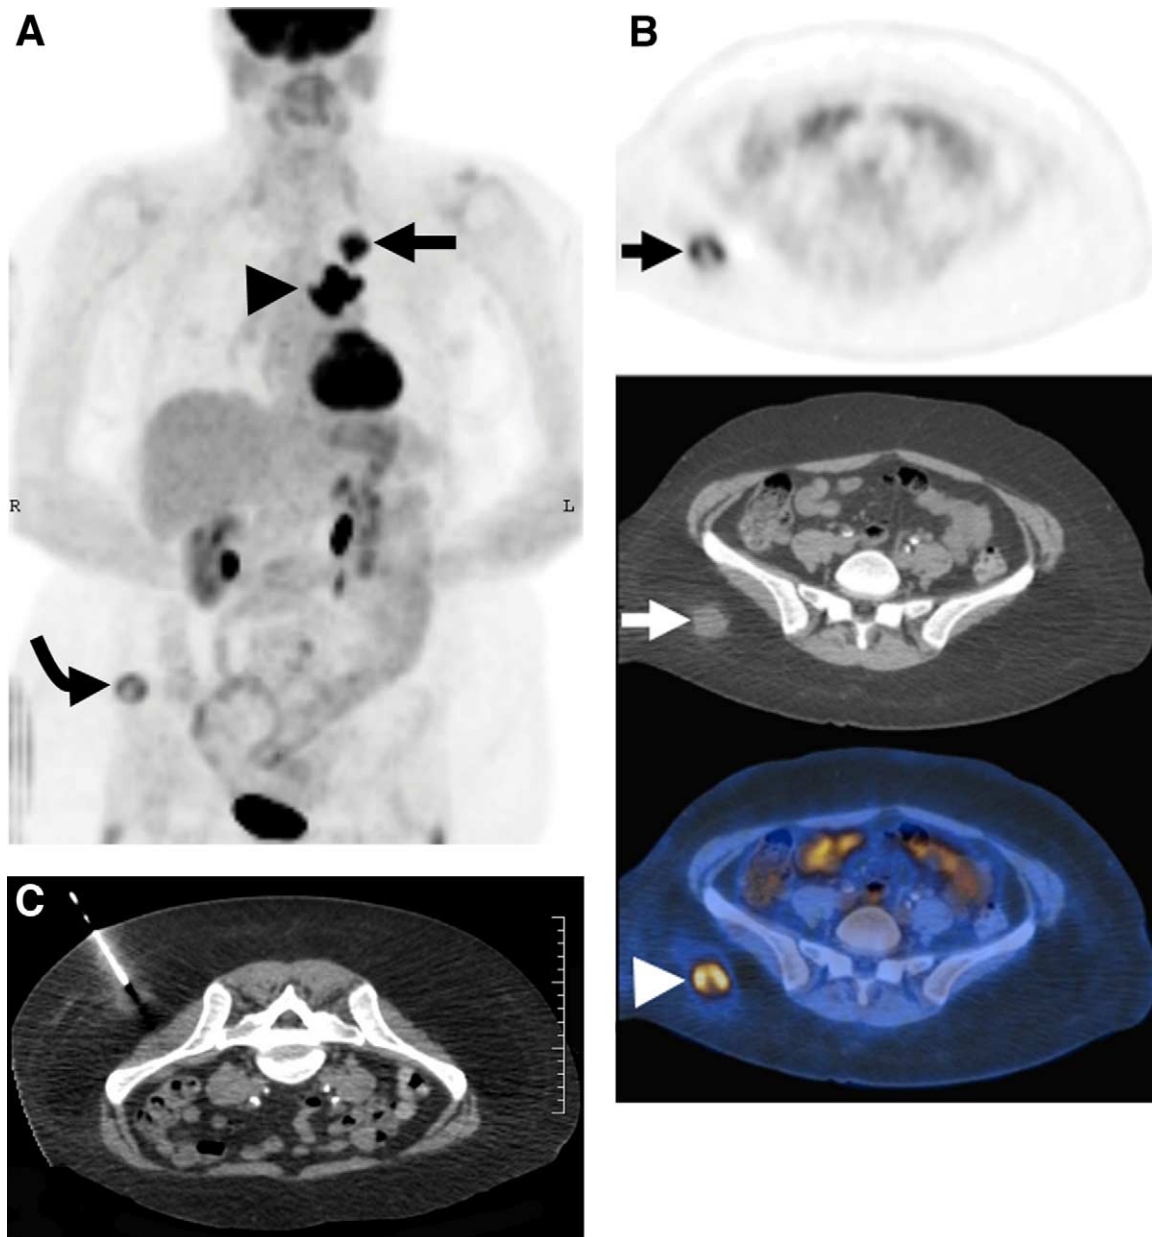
Unusual site of metastatic NSCLC. A 50-year-old subject with newly diagnosed lung carcinoma. (A) Frontal MIP image from an FDG-PET scan, showing that in addition to the left upper lobe lung cancer (arrow) with left mediastinal adenopathy (arrowhead), there is a hypermetabolic mass in the right flank (curved arrow). (B) PET/CT fusion images showing that the hypermetabolic flank lesion (black arrow) corresponds to a soft tissue nodule located deep in the subcutaneous fat of the right gluteal region (white arrow and arrowhead). (C) Representative axial image obtained during CT-guided percutaneous biopsy of the flank mass. Pathology revealed metastatic grade 4 nonsmall cell lung carcinoma, confirming stage IV disease.
